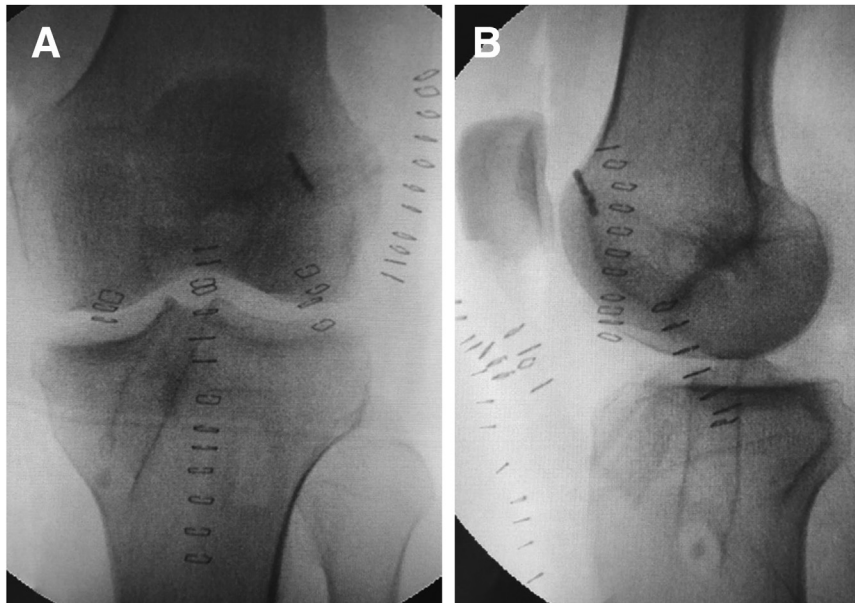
Immediate postoperative radiographs, anteroposterior (A) and lateral (B) of the revision technique of anterior cruciate ligamentoplasty with the bone-tendon-bone graft and Lemaire's extra-articular tendon with a single femoral tunnel.
